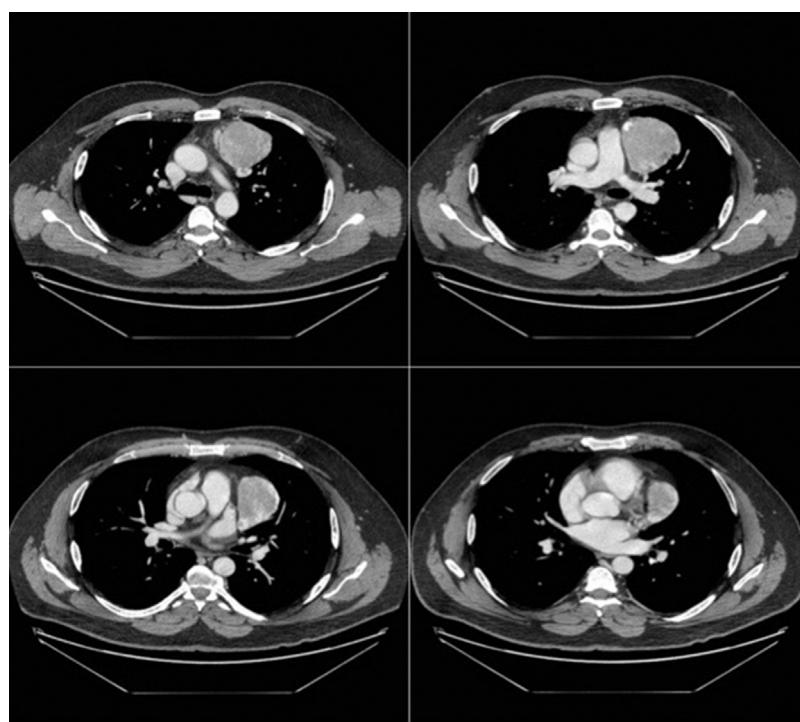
Contrast-enhanced computed tomography scan shows a left heterogeneous mediastinal mass.
